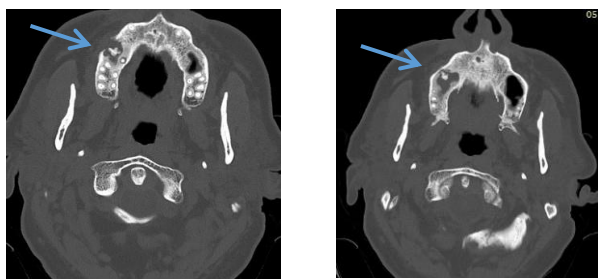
Axial CT Scan. Bone window. 15 right dental abscesses with lysis of the right maxilar floor and acute maxilar sinusitis (blue arrow).
